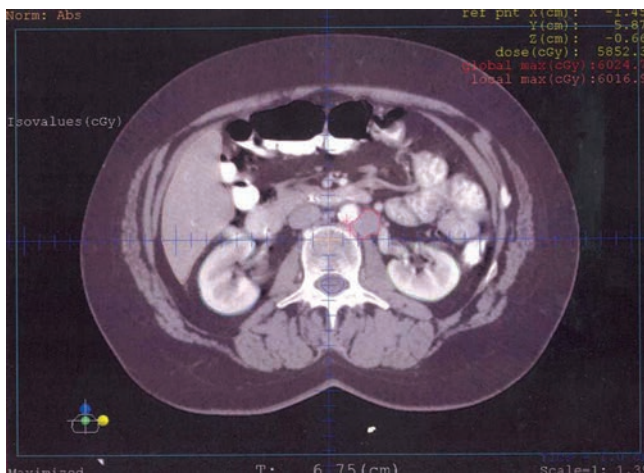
Axial CT scan demonstrating an enlarged periaortic lymph node near the left renal hilum.
